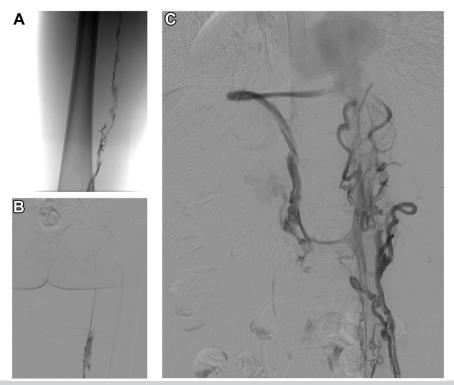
A-C, Computed tomography venograms demonstrating bilateral iliac vein thrombosis, absence of inferior vena cava (IVC) filling, and extensive tortuous collateral vessels with extension from the pelvic veins to the azygos vein.
